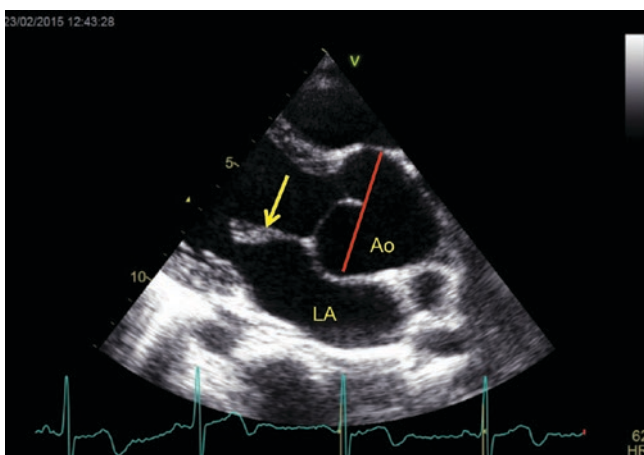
Transthoracic echocardiography image of an aortic sinus of Valsalva aneurysm in a 15-year-old boy with Marfan syndrome. Note the pear-shaped aortic root and the thickened mitral valve leaflets (arrow). *Ao* aorta, *LA* left atrium
